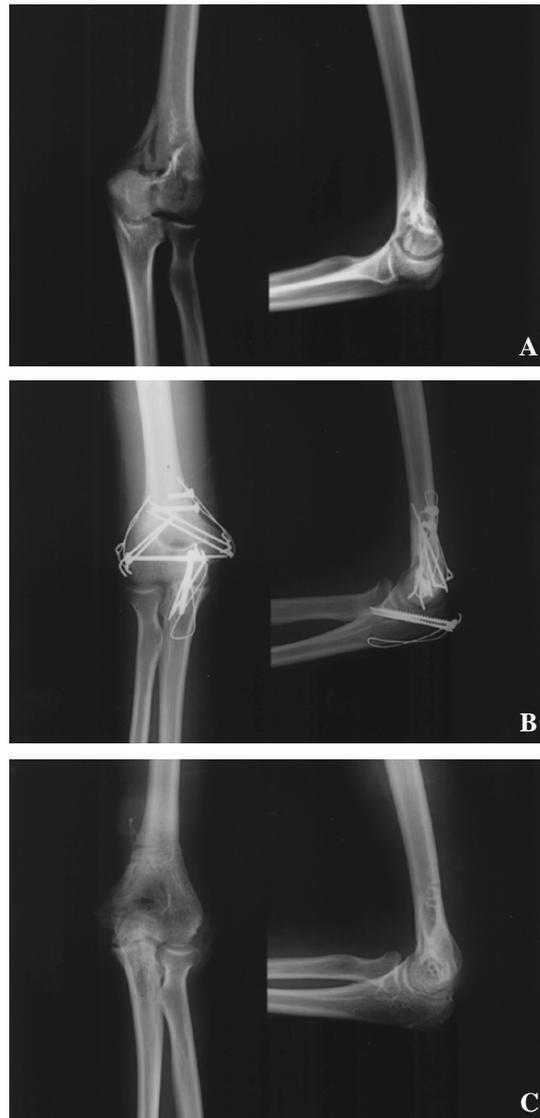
Preoperative radiographs (A) of a 70-year-old man with a C2 fracture by AO classification. Postoperative radiographs were taken after triple tension band osteosynthesis with olecranon osteotomy to provide direct visualization of the distal humerus articular surface for exact anatomic reduction (B). One year later, radiographs were taken after removal of hardware and elbow function was completely recovered (C).
